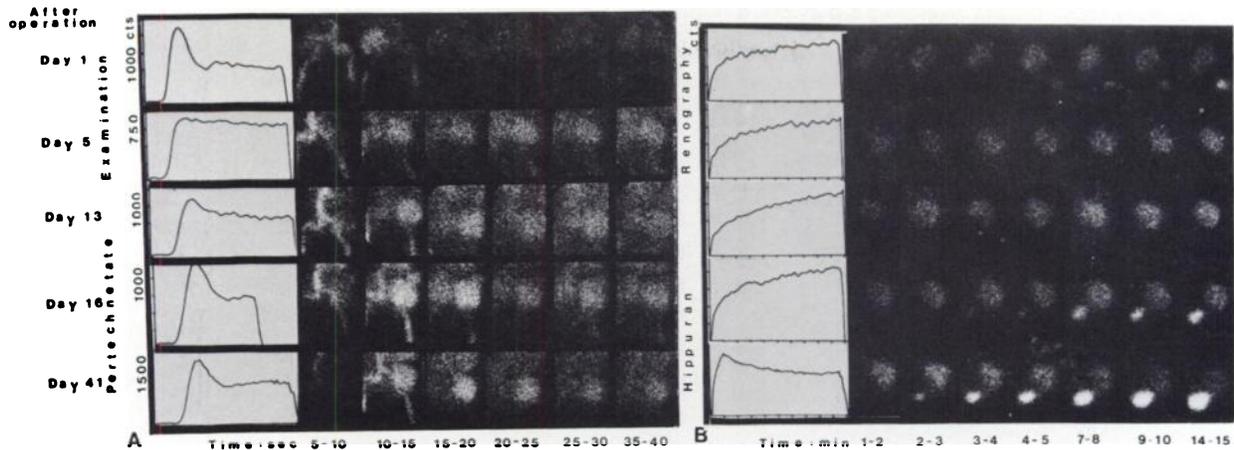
(A) Serial pertechnetate scintigraphy and time-activity curves of patient incurring rejection episode on Day 5 after graft implantation. Improvement of perfusion pattern accompanies successful immunosuppressive therapy, clearly visible on Day 13. (B) Sequence of emission renograms. The rejection episode on Day 5 was accompanied by oliguria, so that tracer failed to appear in bladder during examination. Scintigram on Day 13 failed to indicate improvement.
